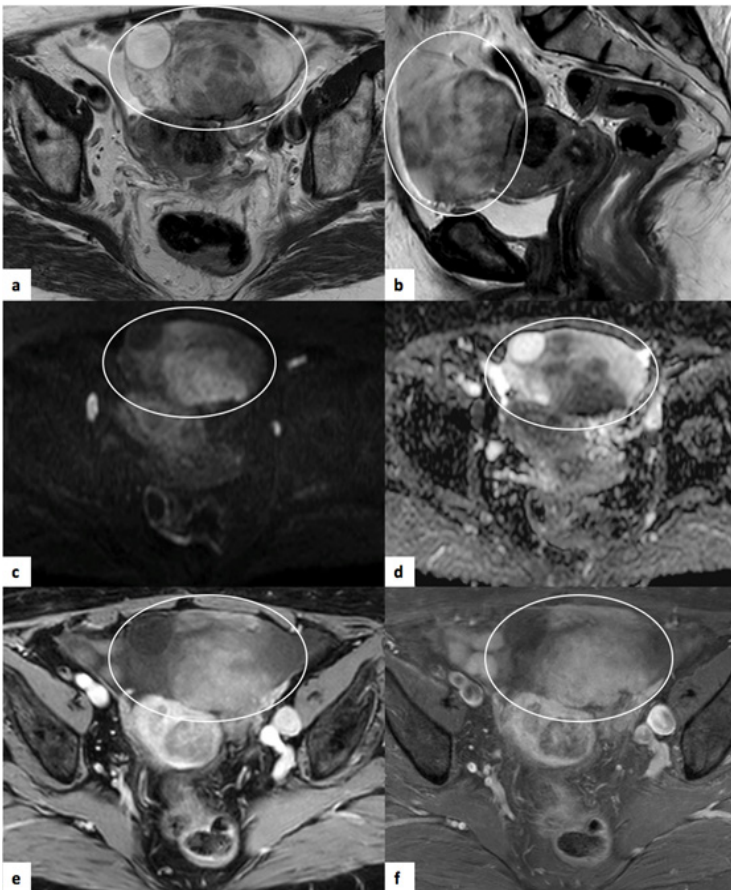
Cellular fibroma of the left ovary. Pelvic MRI of a 60-year-old woman. (a) and (b) Axial and sagittal T2-weighted images, respectively, where it is possible to observe a heterogeneous tumour (circle), of mixed nature, with multicystic component and solid regions of intermediate T2 signal. (c) and (d) DWI ($b=1000$) and ADC map, respectively, showing restricted diffusion of the solid component. In the study after intravenous contrast - axial T1 SPAIR (e) and in the delayed axial acquisition SPIR (f) there is heterogeneous enhancement of the solid component. The anatomopathological study revealed a cellular fibroma.
